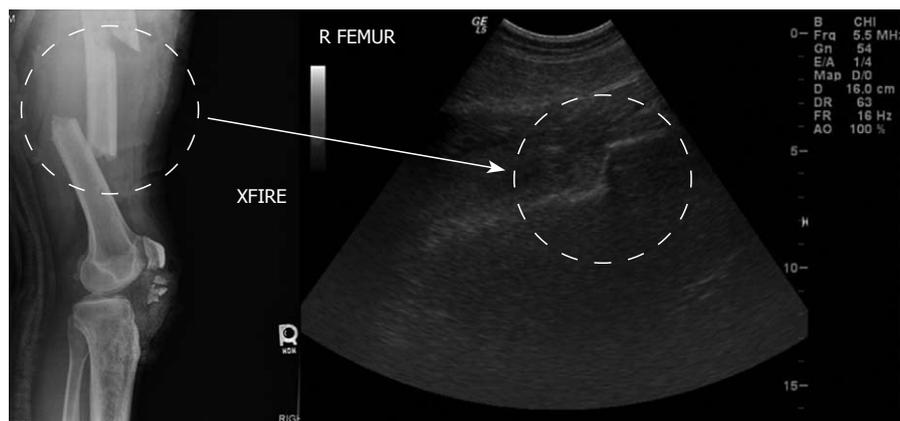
Bedside sonographic appearance of a displaced femoral fracture. A correlation to plain radiography is shown. Bedside sonography provides a viable tool for quick and reliable assessment of suspected long-bone fractures. R FEMUR: Right femur; XFIRE: Cross table film.
